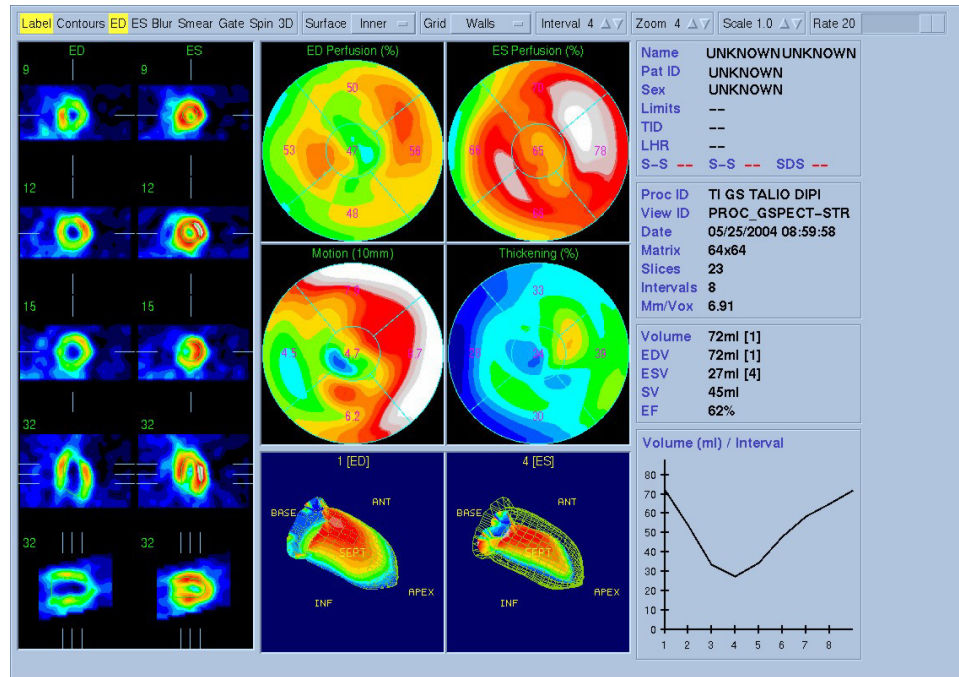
Screenshot from the result page of a cardiac SPECT study. Some slices are shown on the left part of the screen. The polar maps (bull's eye) are shown on the upper middle and below, the three-dimensional surfaces in diastole and systole. (Screenshot taken from QGS – Guido Germano.)
